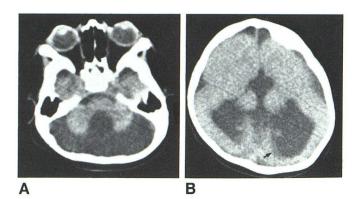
Case 9 (case 2 in [3]). Cerebrocerebellar lissencephaly variant. A, CT scan. B, Higher cut. Typical figure-eight appearance of cerebrum and striking hypoplasia of cerebellar hemispheres with apparently absent vermis. Smooth subsurface line (*arrow*).
